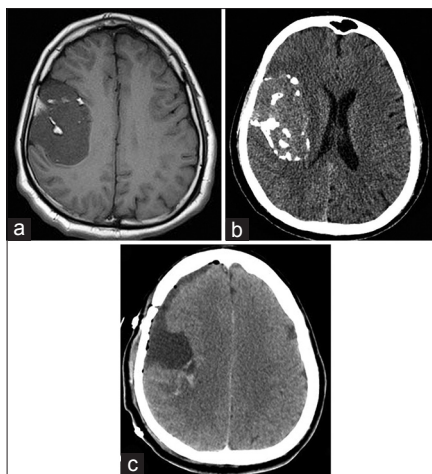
(a) Magnetic resonance imaging brain shows a large well defined lobulated extra axial lesion in right fronto-sylvian region with broad base to inner skull vault and dura. (b) Dense calcification seen in computed tomography. (c) Post-operative CT image showing grade I excision
